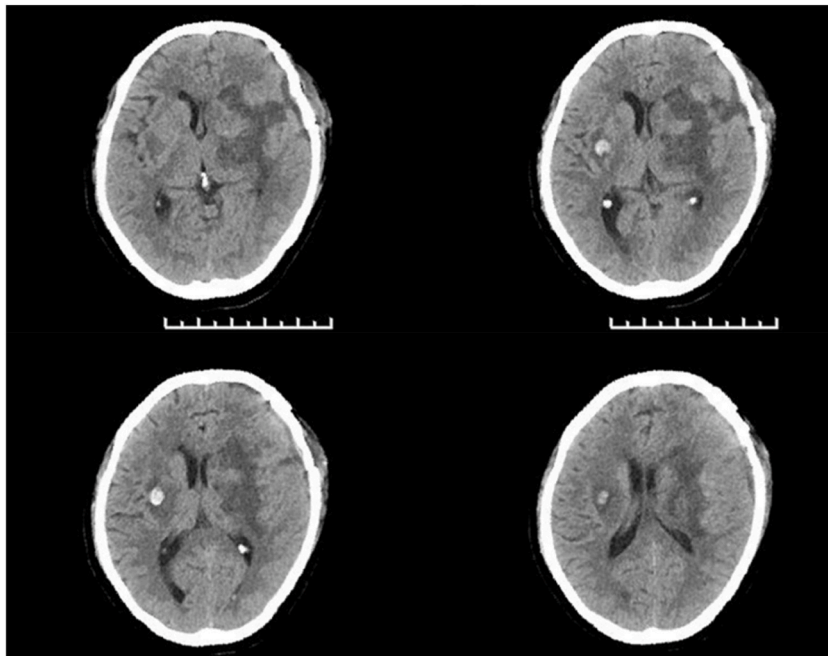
On the 28th day after operation, CT head examination showed that cerebral edema was reduced, midline structure was generally normal, ventricular compression was improved, and subdural effusion/hematoma was absorbed on the left frontal and parietal.
